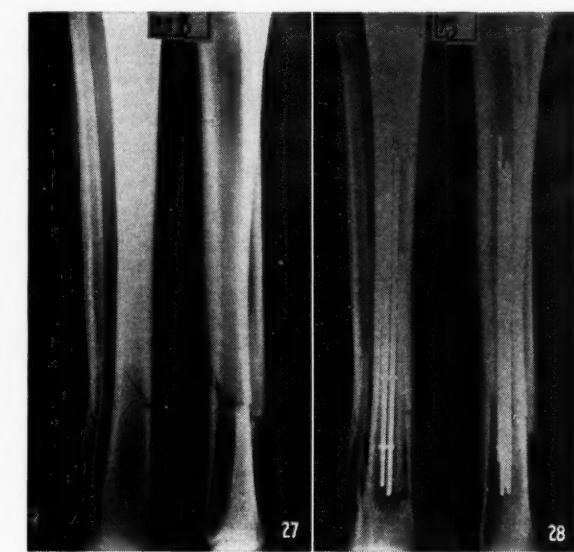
Case No. 6. Pre-operative X-ray.
